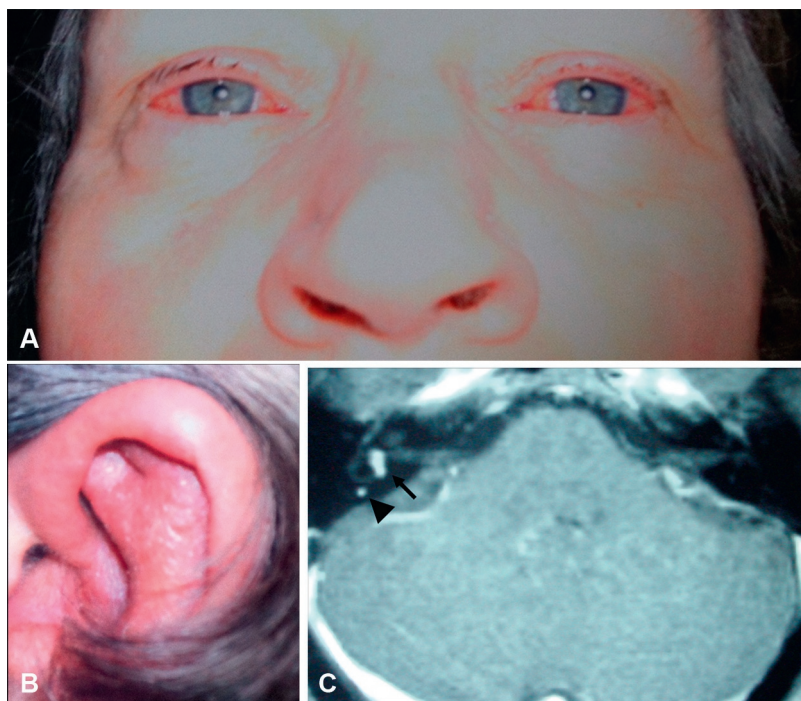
Relapsing polychondritis. Typical bilateral eye (A) and ear (B) inflammation in relapsing polychondritis. Axial magnetic resonance imaging (MRI) scan (C) in another patient suffering from relapsing polychondritis who complained of a right sudden deafness and vertigo with a right peripheral vestibular deficit. Axial MRI scan (C) shows enhancement of the right vestibule (arrow) and posterior canal (arrowhead) after gadolinium administration in keeping with labyrinthitis in the context of relapsing polychondritis. The alternative diagnosis was an intralabyrinthine schwannoma that can be excluded by the development of a right labyrinth ossification on imaging follow-up.
